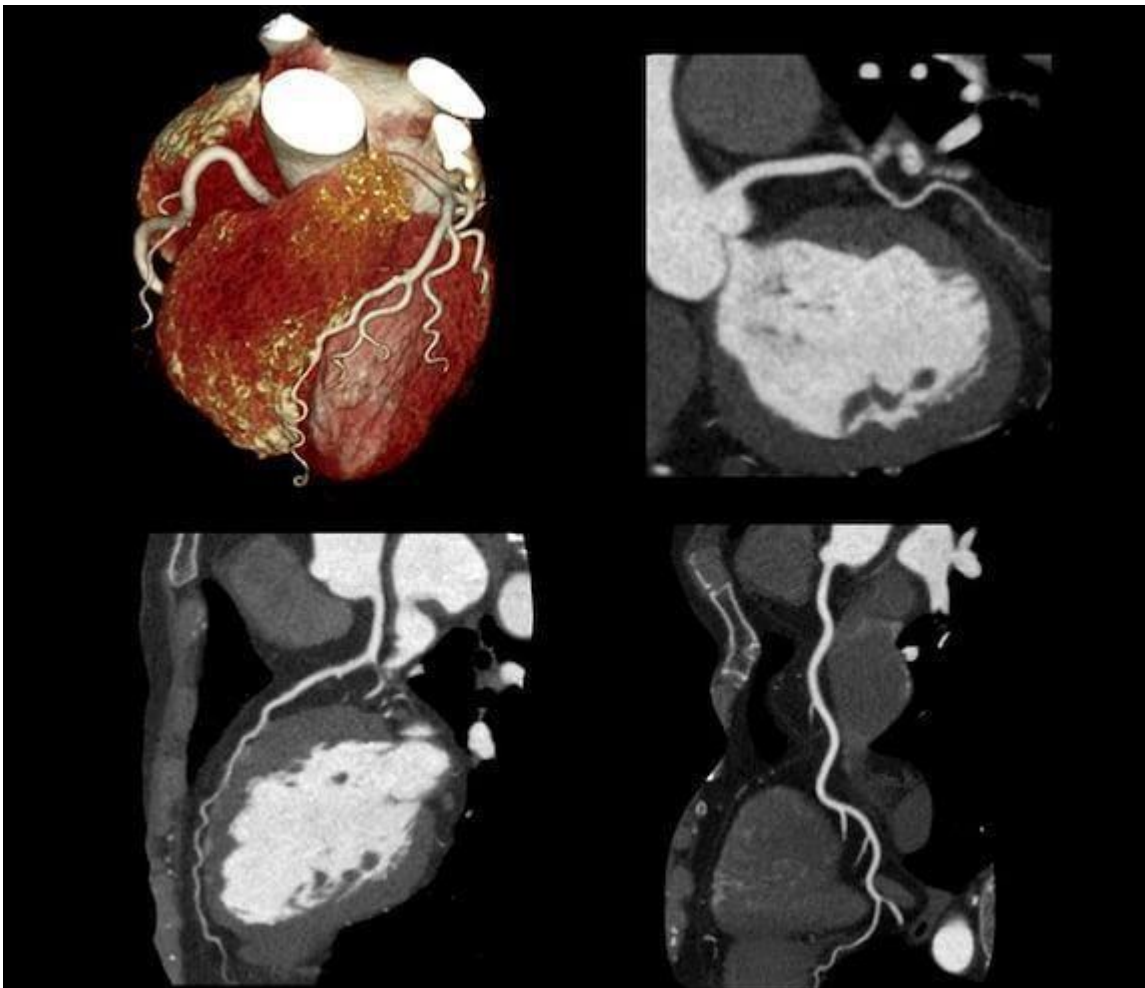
Cardiac coronary computed tomography angiography (CCTA)
